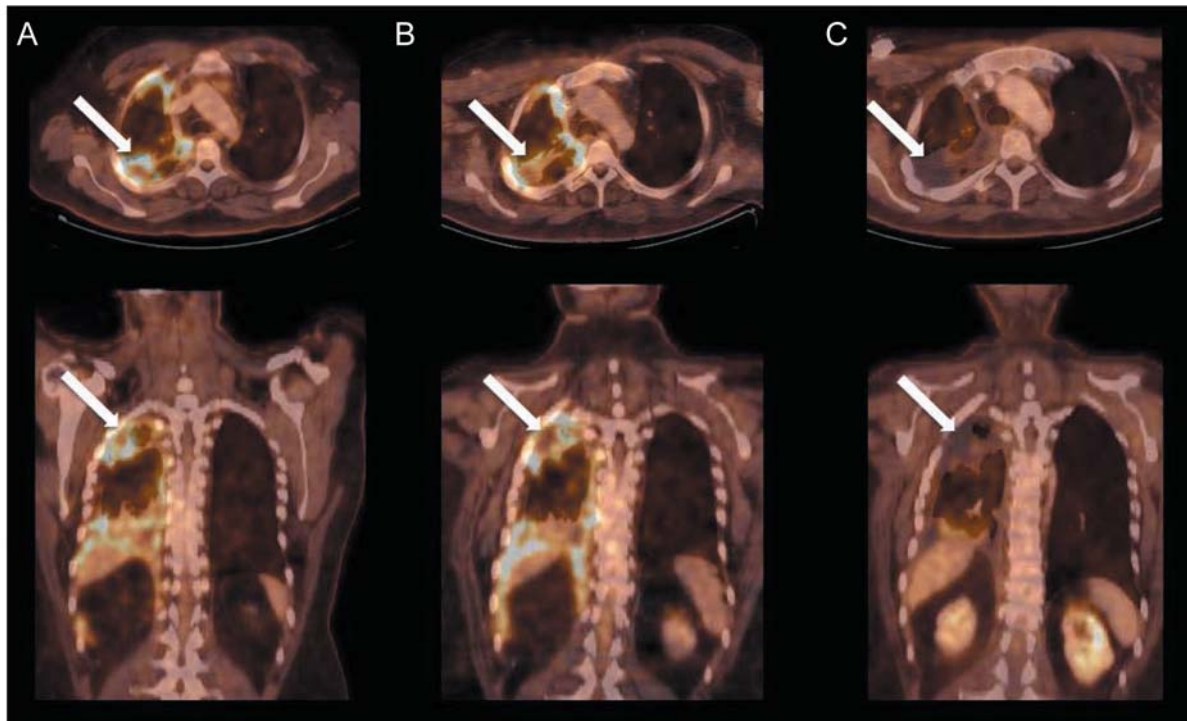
Transverse and coronal ^{18}F -fluoro-deoxyglucose positron-emission tomography-computed tomographic images at baseline (A), after six cycles of chemotherapy (B) and 6 months of pazopanib treatment (C). The standard uptake value (arrows point at locations of measurements) at baseline, after six cycles of chemotherapy and 6 months of pazopanib treatment were 11.7, 12.6 and 4.6, respectively.
